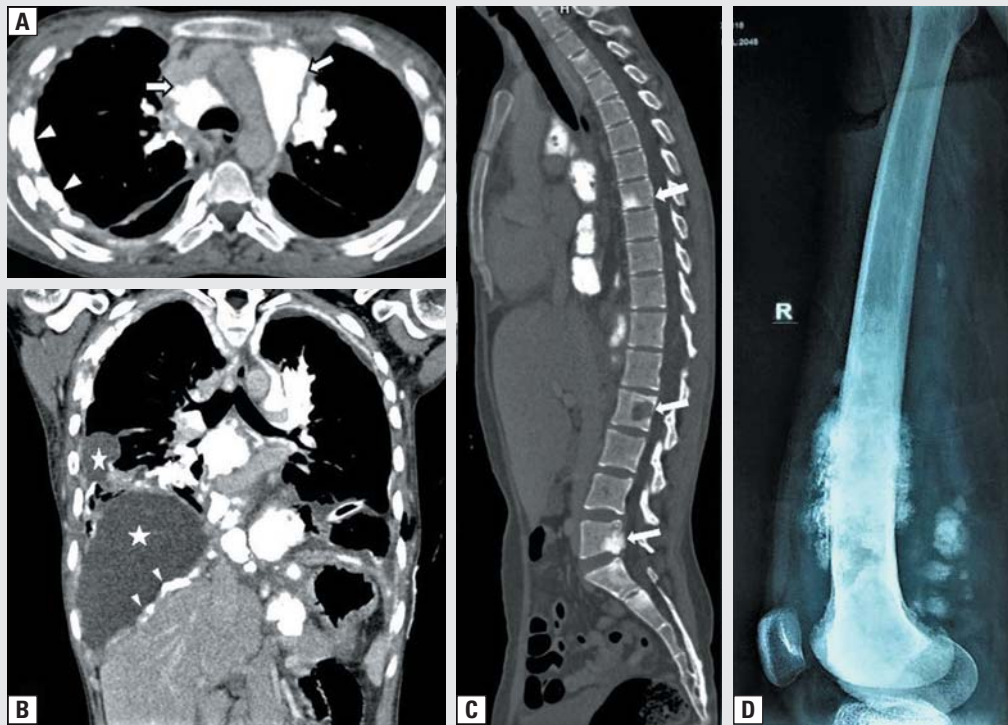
Axial CECT at the level of aortic arch (A.) shows multiple large calcified paraaortic and pre-tracheal lymph nodes (arrows), irregular right sided pleural thickening and calcification (arrowheads). Coronal (B.) and sagittal bone window (C.) reformatted images show extensive mediastinal, perivascular, gastrohepatic metastatic calcified lymphadenopathy, extensive pleural calcification including bilateral diaphragmatic pleura (narrow arrowheads in B.), multiple bilateral loculated pleural effusion (stars in B.), lytic and sclerotic metastasis in vertebrae (arrows in C.). In the same patient, x-ray of right thigh lateral view (D.) shows bone tumour with aggressive periosteal reaction at distal femoral metaphysis
